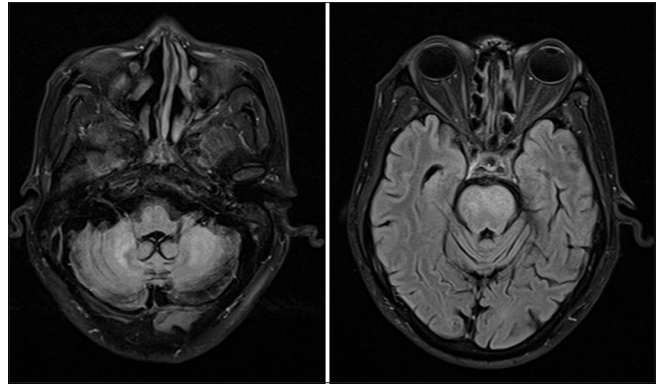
Magnetic resonance imaging shows diffuse cerebral atrophy with fluid attenuated inversion recovery hyperintensities in the brain stem and cerebellum
